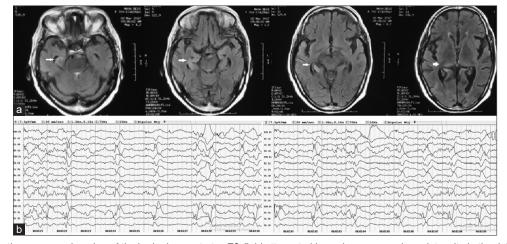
(a) Magnetic resonance imaging of the brain demonstrates T2-fluid attenuated inversion recovery hyperintensity in the right temporoparietal, right thalamic, and pulvinar areas. (b) Electroencephalography showing right temporal spikes with intermittent attenuation of background
